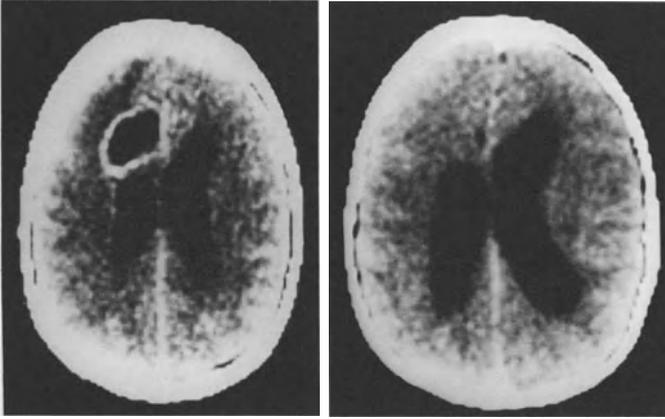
Patient No. 2 from Table 2 CT-scan, brain abscess frontal.
